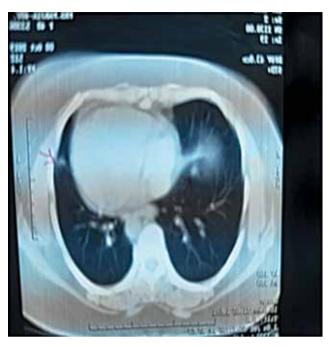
CT scan of chest showing two pulmonary nodules
